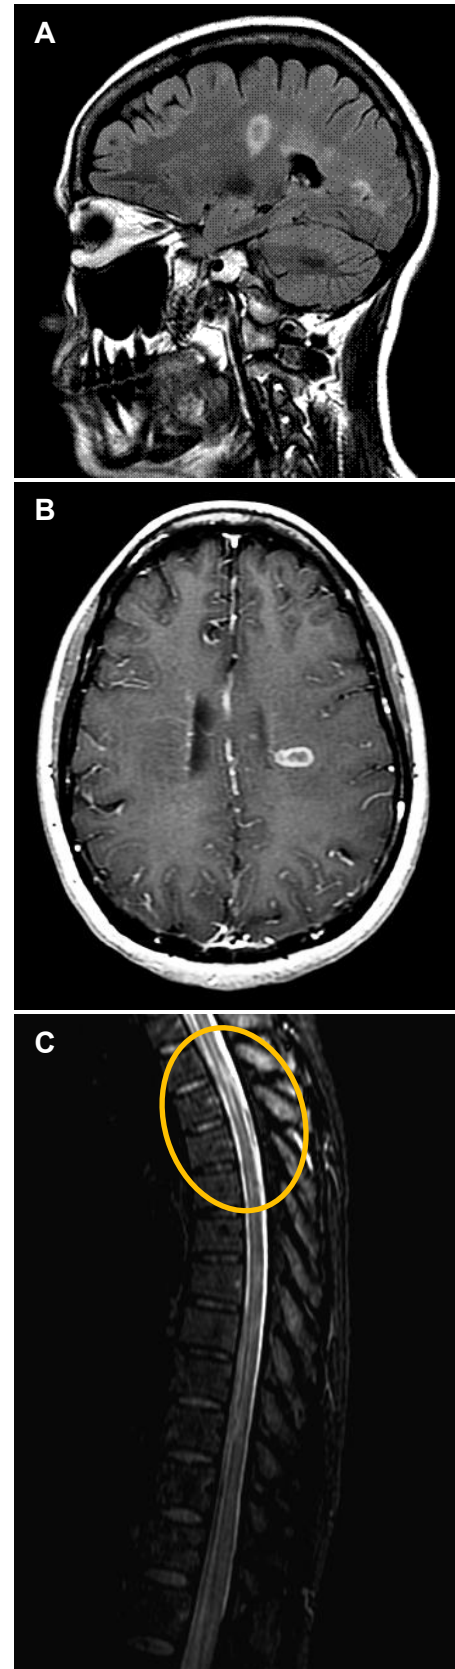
(A) Sagittal T2 FLAIR. (B) Axial T2 FLAIR. Both images demonstrate MS plaques in the periventricular white matter. (C) Sagittal STIR of the thoracic spine demonstrating plaque appearance (circle).
